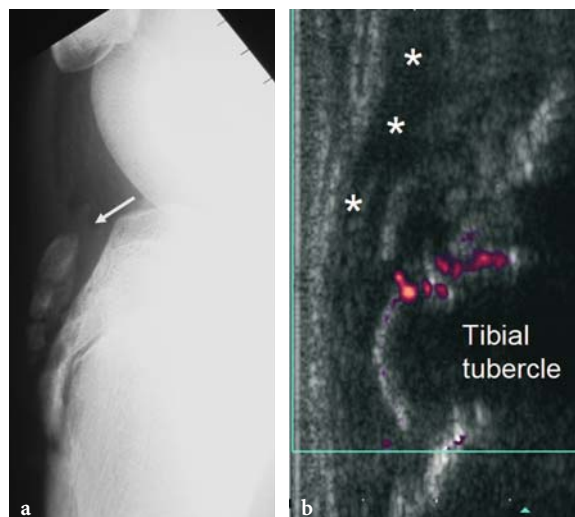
Osgood Schlatter's disease. a) plain film; b) ultrasound showing fragmentation of the tibial tubercle. An infrapatellar effusion can be seen on the radiograph (arrow). On ultrasound the distal end of the tendon is seen to be widened and hypoechoic. There is hypervascularity around the bony fragments. Asterisks mark the tendon
